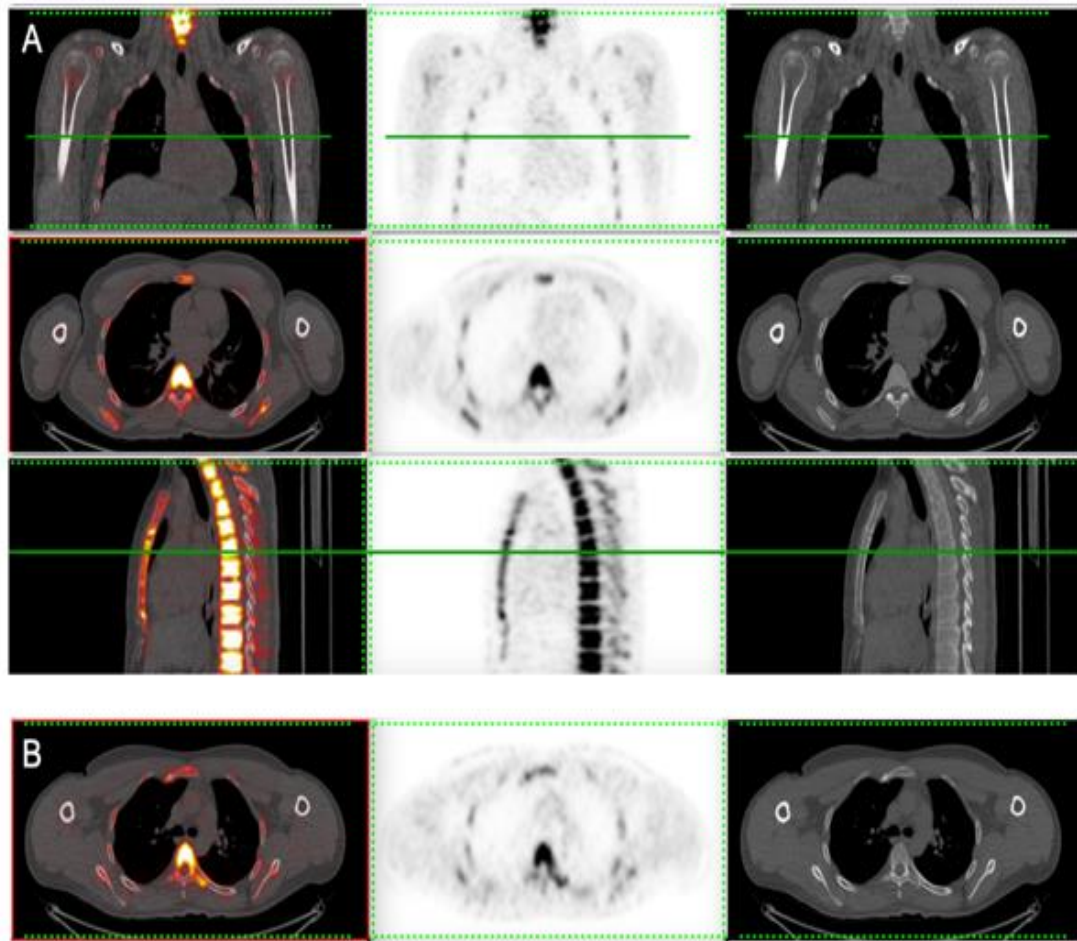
^{18}F -NaF PET/CT images for a 33 year old, male AKU patient.
